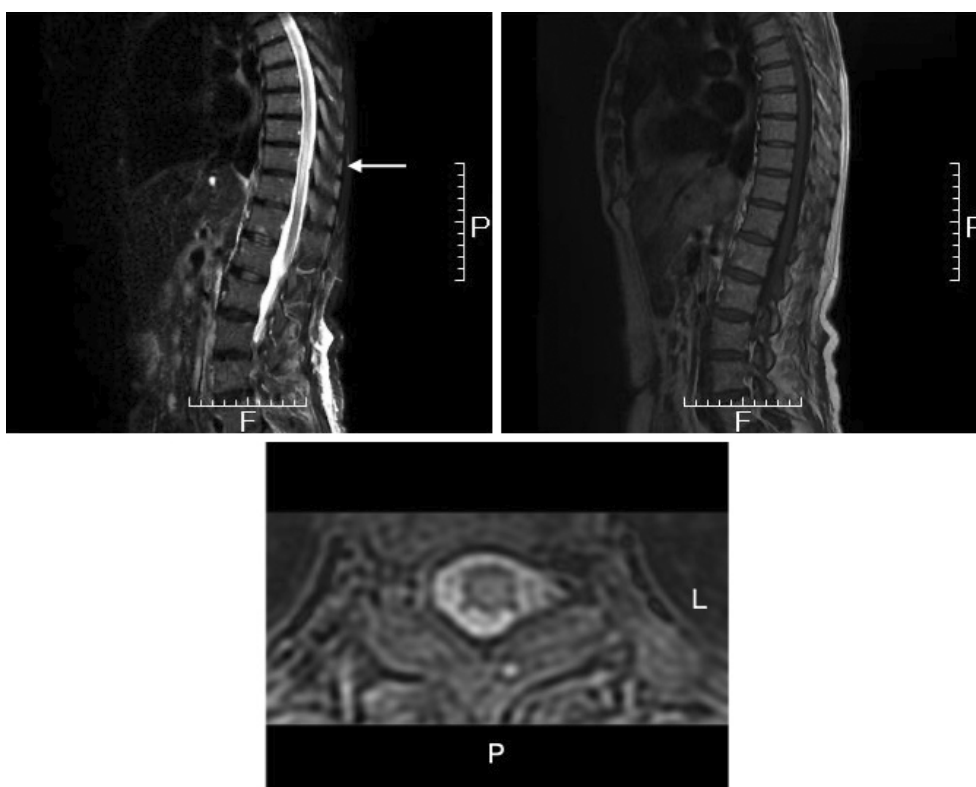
MRI scans of the spinal cord on postoperative day 6 after the second operation
